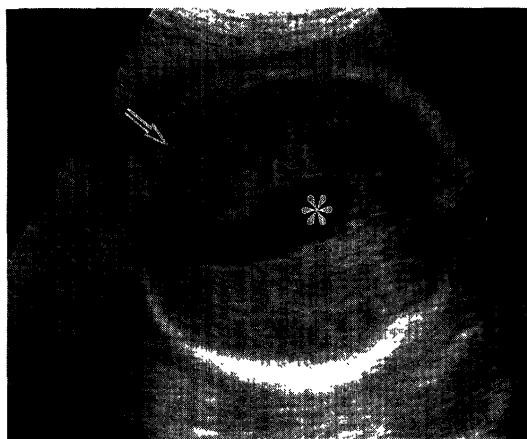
Doppler sonogram at a gestation period of 34 weeks revealing a large cystic lesion 19 mm in diameter (*asterisk*) at the center of the head, corresponding to the aneurysmal sac of the vein of Galen aneurysmal malformation, and the transverse sinus (*arrow*).
